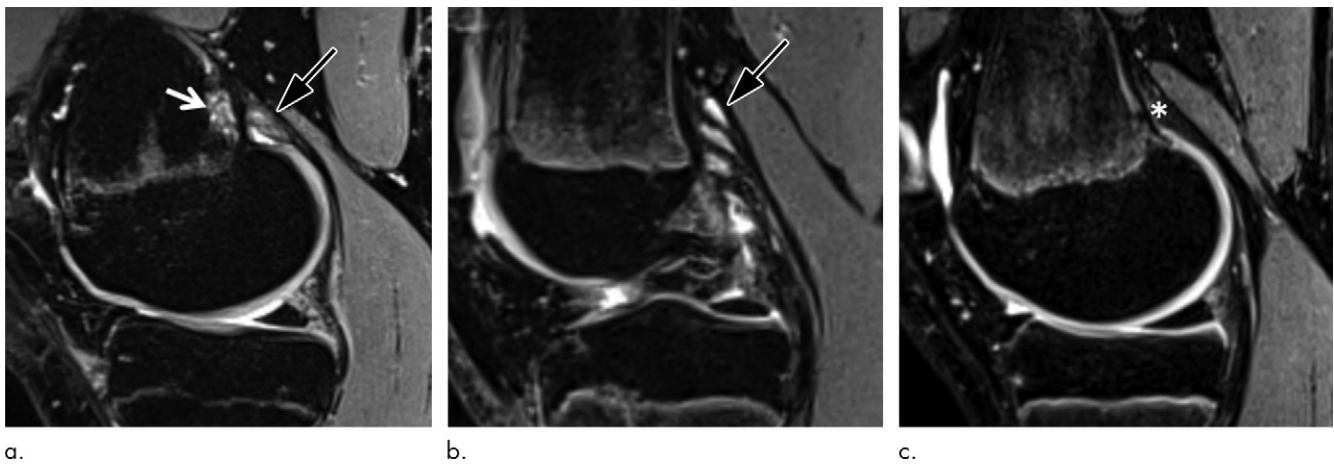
(a) Sagittal fat-suppressed T2-weighted MRI scan in a 14-year-old male competitive skier shows a distal femoral cortical irregularity (DFCI) (white arrow) at the level of the tendon attachment of the medial head of the gastrocnemius muscle (MHG), which shows increased signal intensity (black arrow). (b) Sagittal fat-suppressed T2-weighted MRI scan in 15-year-old male competitive skier with a small DFCI (not shown) and cystic changes of the proximal MHG tendon (arrow). (c) Sagittal fat-suppressed T2-weighted MRI scan in 15-year-old male competitive skier with no DFCI and no signal intensity or cystic changes of the MHG tendon (*) for comparison.
